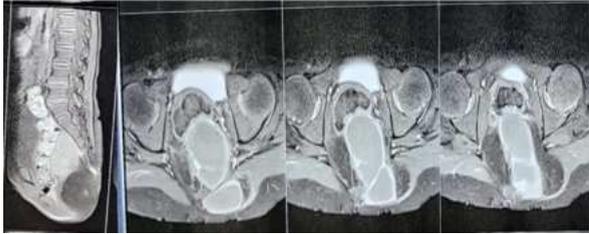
Magnetic Resonance Imaging of the Sacrococcygeal Teratoma
